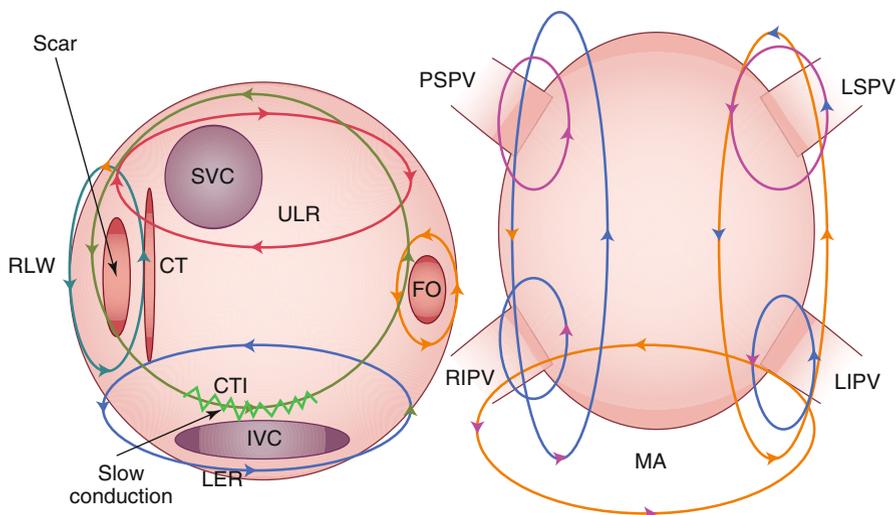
Location of Atrial Flutters in the Right and Left Atrium. Cavotricuspid Isthmus (CTI) dependent circulates around the right atrium commonly with counterclockwise propagation (green arrows). Upper loop re-entry (ULR) rotates around the superior vena cava (SVC) with slow conduction through the crista terminalis (CT). Lower loop re-entry rotates around the inferior vena cava (IVC) also involving the crista terminalis (CT). Re-entry may also occur around the right lateral wall (RLW) often in post surgical cases where this is related to an incision as well as around the fossa ovalis (FO). In the left atrium atrial flutter may occur around the mitral annulus (MA) in either a clockwise or counterclockwise direction as well as around the pulmonary veins (LSPV left superior pulmonary vein, LIPV left inferior pulmonary vein, RSPV right superior pulmonary vein, RIPV right inferior pulmonary vein)
